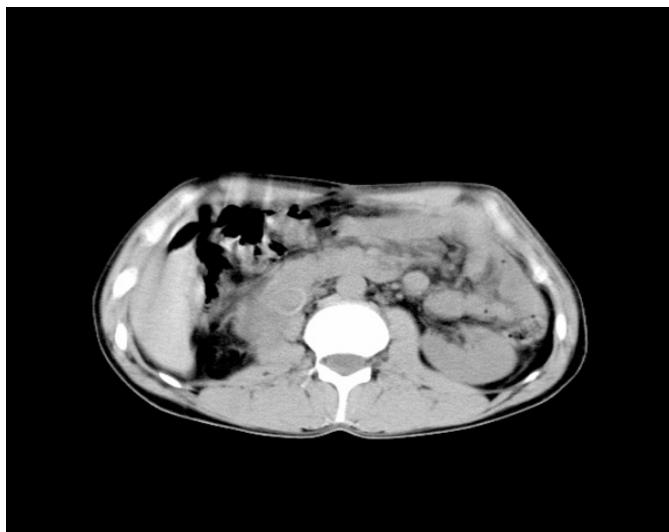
Abdominal computed tomography and vascular graft in the inferior vena cava.
